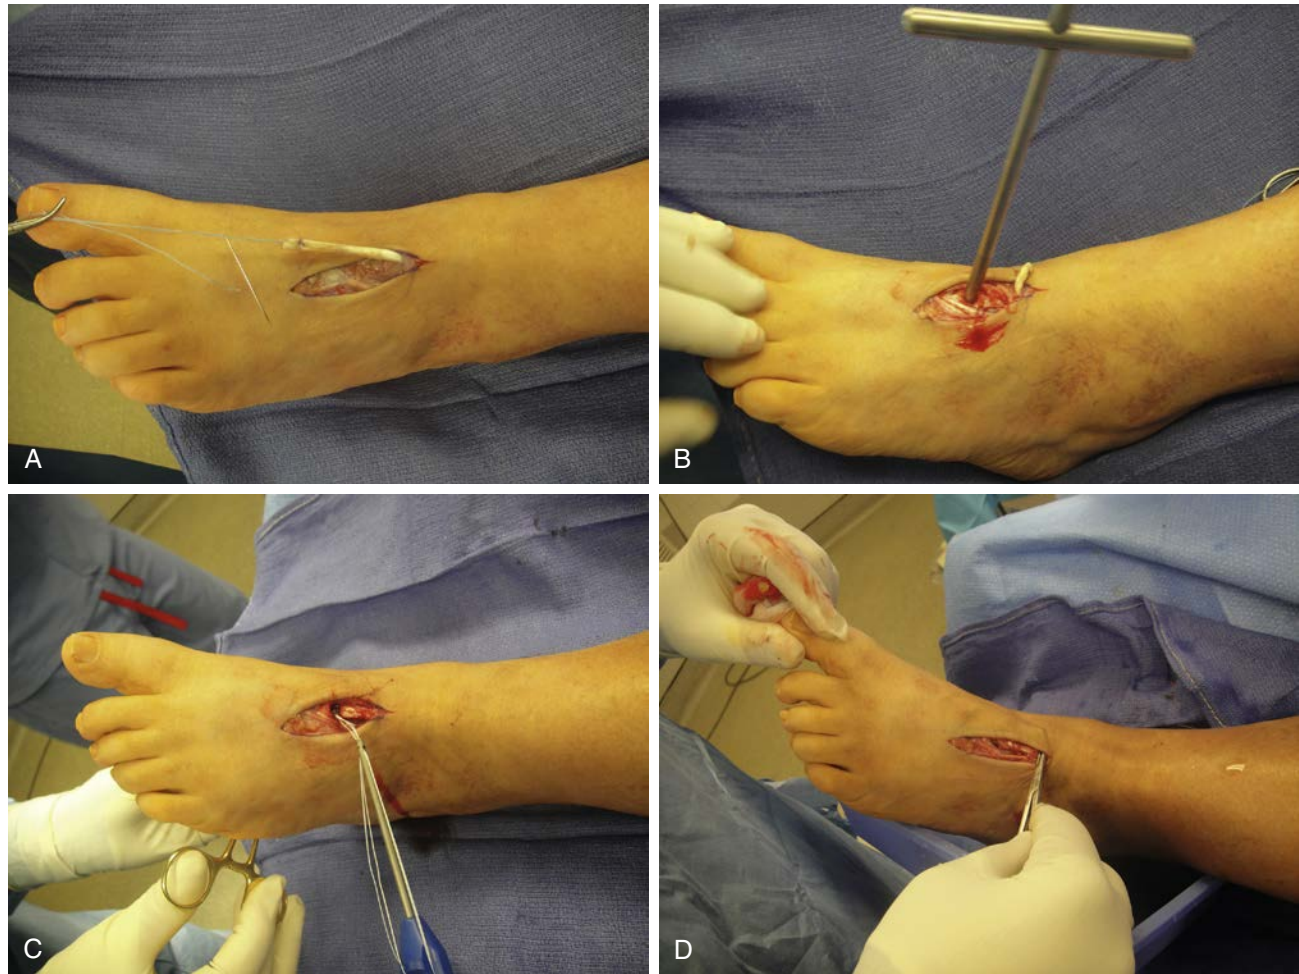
In this case, the anterior tibial tendon (ATT) was so severely scarred and associated with fatty infiltration of the proximal muscle on magnetic resonance imaging (MRI) that we went directly to the extensor hallucis longus (EHL) transfer without opening the ATT sheath. (A) The EHL is cut in the midfoot leaving sufficient length to pass through a drill hole in the middle cuneiform. (B) A tunnel is made in the middle cuneiform using a hand reamer that removes a 7-mm diameter of bone. (C) A needle is attached to the suture on the EHL and passed through the cored hole, into which a suture anchor has been inserted prior to passing the EHL tendon. (D) The tendon is then pulled into the hole and tensioned with the foot in 10 degrees of dorsiflexion and sutured.
